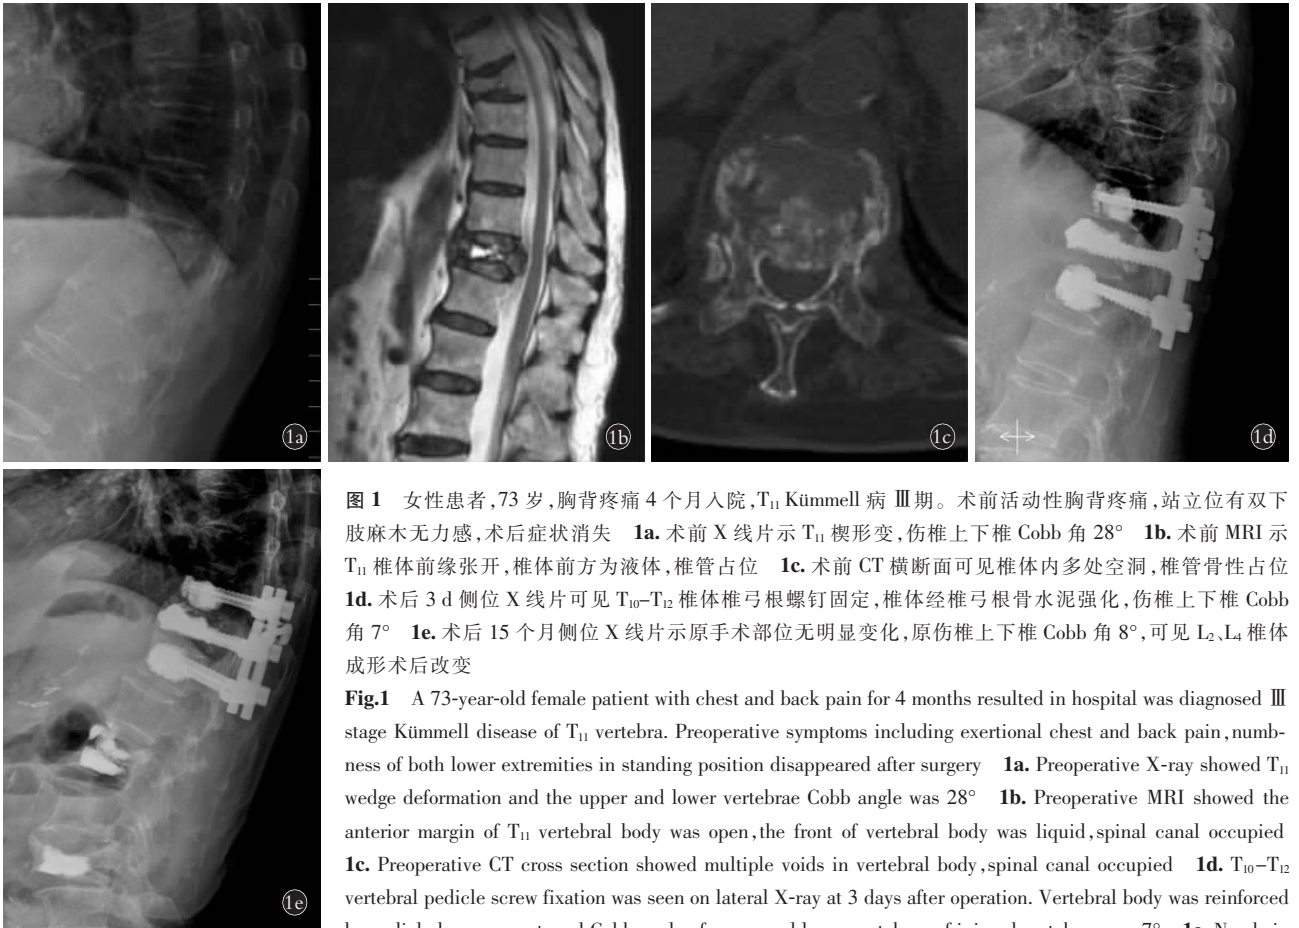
女性患者, 73 岁, 胸背疼痛 4 个月入院, T₁₁ Kümmell 病 III 期。术前活动性胸背疼痛, 站立位有双下肢麻木无力感, 术后症状消失 1a. 术前 X 线片示 T₁₁ 楔形变, 伤椎上下椎 Cobb 角 28° 1b. 术前 MRI 示 T₁₁ 椎体前缘张开, 椎体前方为液体, 椎管占位 1c. 术前 CT 横断面可见椎体内多处空洞, 椎管骨性占位 1d. 术后 3 d 侧位 X 线片可见 T₁₀-T₁₂ 椎体椎弓根螺钉固定, 椎体经椎弓根骨水泥强化, 伤椎上下椎 Cobb 角 7° 1e. 术后 15 个月侧位 X 线片示原手术部位无明显变化, 原伤椎上下椎 Cobb 角 8°, 可见 L₂、L₄ 椎体成形术后改变
